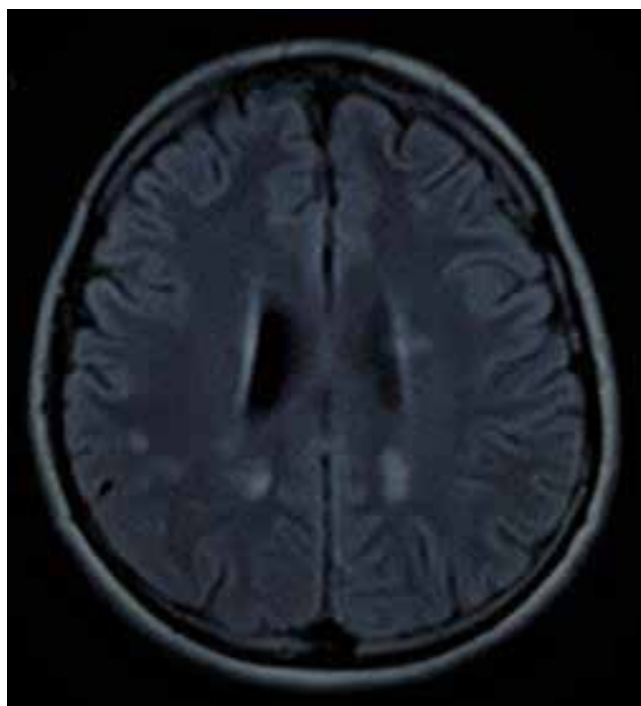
Ischemic/demyelinating lesions in bilateral periventricular white matter in MRI flair axial sections
